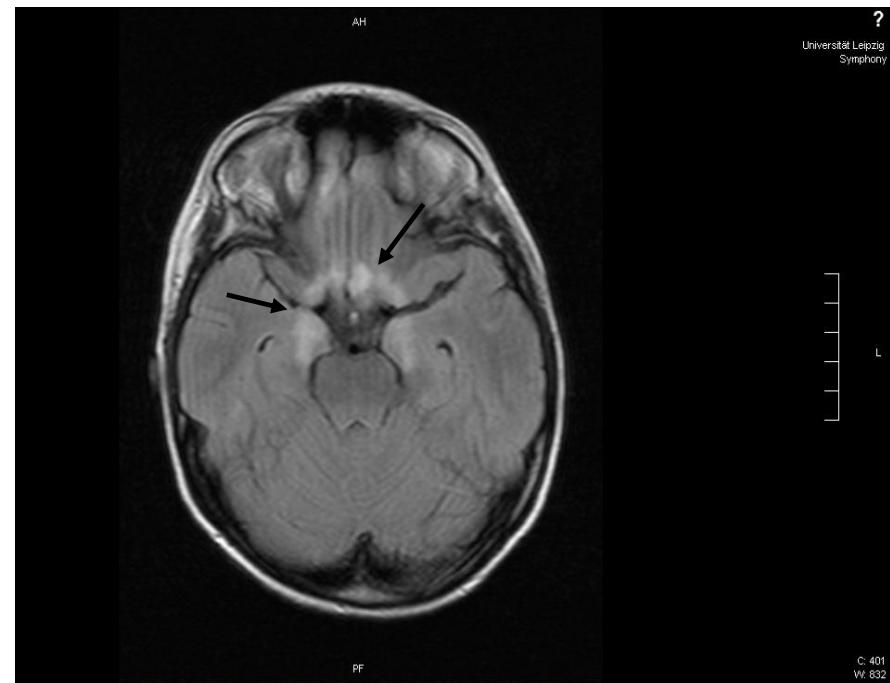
Cranial magnetic resonance imaging of a 14-year-old child with new onset of type 1 diabetes (three days after therapy start) showing multifocal hyperdense lesions in the left thalamus (a; solid arrows) and temporomesial in both sides of the thalamus with affections of the paraterminal gyrus of the frontal lobe (b; solid arrows), also bilateral in the praecuneus (a; discontinued arrows) without contrast medium enhancement – compatible with extrapontine myelinolysis
